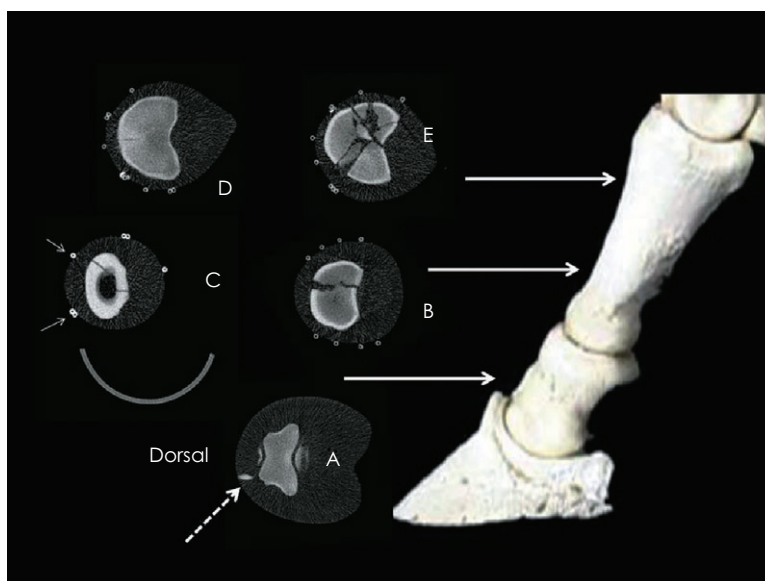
Cases where CT was performed for surgical planning: (A) foreign body (dotted white arrow) at the coronary band; (B, C, D, E) complete sagittal, spiral, simple incomplete, comminuted fractures of P1. Note the radiopaque markers (plain small arrows).
